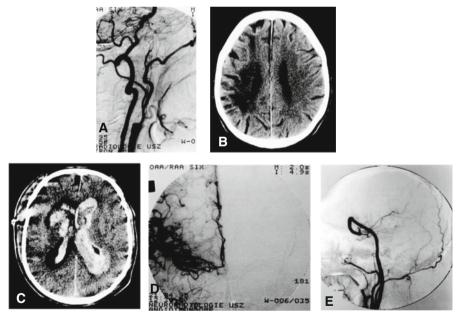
High-flow venous graft bypass between the right common carotid artery and the MCA (M2). 58-year-old male with right ICA occlusion (A) with an extensive infarction on the right hemisphere (B) underwent this bypass surgery, as the STA as donor artery was not available. After an uneventful postoperative course, sudden neurological deterioration occurred on the 3rd postoperative day. The CT scan displayed bleeding into the infarcted area along with hematocephalus (C); and digital subtraction angiography, a patent high-flow bypass (D, E)
